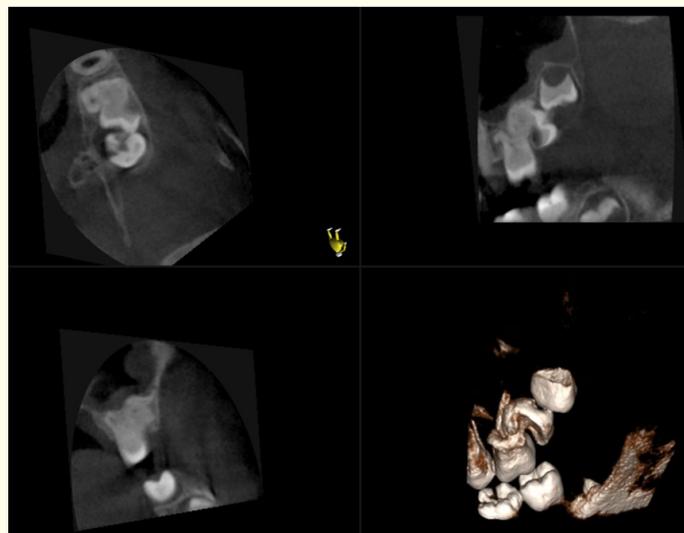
Caption: Axial, sagittal, coronal and three-dimensional views of a cone-beam CT scan of the maxilla taken showing the abnormal relationship of the upper left first, second and third molars.
